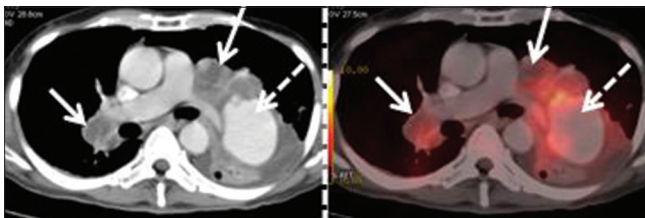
Axial positron emission tomography/computed tomography images of chest showing multiple metabolically active enlarged mediastinal lymphadenopathy with conglomeration and central necrosis (arrows) and a contrast filled cavitary area amidst the necrotic lymph nodal mass devoid of any fluoro deoxy glucose avidity (dotted arrow)
